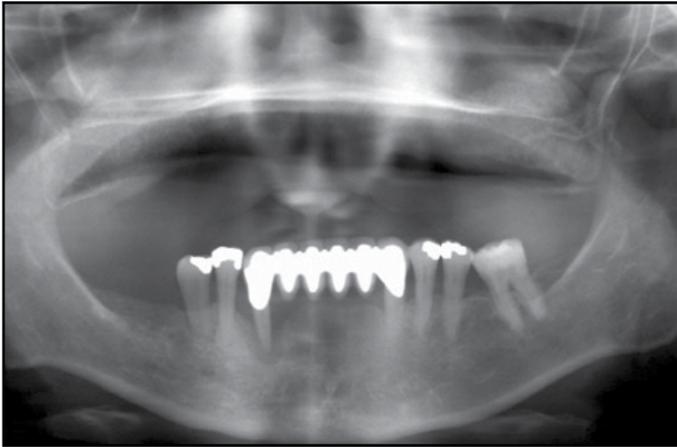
4 month post-surgical panoramic radiograph
